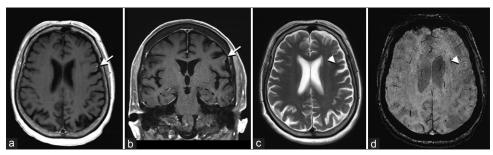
After 1 week, follow-up brain magnetic resonance imaging showed nearly complete resolution of the abnormal enhancement (arrows) in contrast-enhanced T1-weighted image (a: axial, b: coronal) with some residual subcortical T2 shortening (arrowhead in c). Complete regression of subcortical hypointensity on susceptibility-weighted image is depicted (arrowhead in d)
